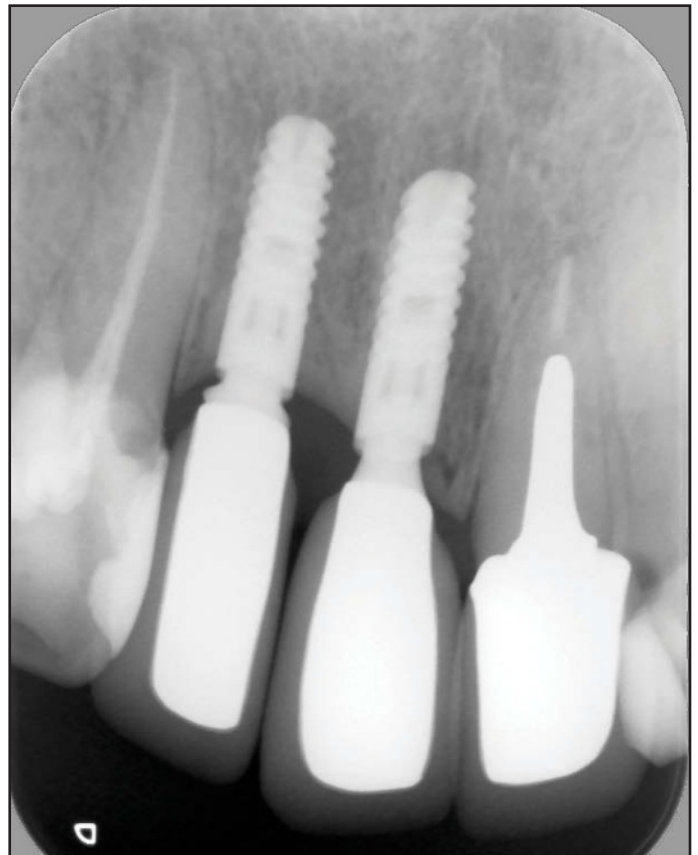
Radiographic image 5 years after implant placement in Case 1.
